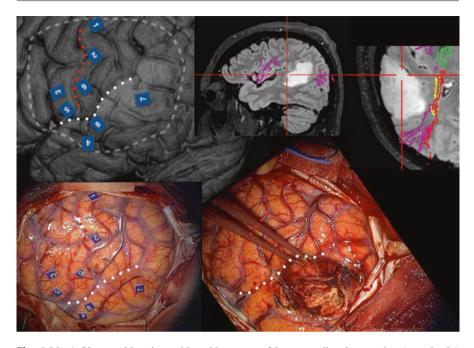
A 30-year-old patient with sudden onset of language disturbances that (completely) resolved after several hours. At time of admission to the hospital, there were no language or other impairments upon neurological examination. In retrospect, the patient reported that he experienced predominantly difficulties in word finding. In later days, the patient experienced auditory hallucinations. These temporary functional disturbances were considered epileptic phenomena. MRI (top *images*) revealed a left temporo-parietal brain tumour (low-grade glioma). MRI-based tractographic information is superimposed on anatomical images (purple, arcuate fasciculus; yellow, inferior fronto-occipital fasciculus; red, optical tract; green, corticospinal tract). The deepest part of the tumour is closely related to language and optical tracts. Dotted lines show the Sylvian fissure (white) and central sulcus (red). Photographs during surgery (bottom images) show the results of cortical stimulation and the extent of resection. Several tasks were used during the mapping procedure: counting, picture naming and auditory comprehension. (1) Sensation in the right hand; (2) sensation within the mouth; (3) number skipped during counting $(31 \dots 50)$; (4) hesitation and speech arrest; (5) speech arrest, "strange feeling" in the mouth; (6) sensation in the tongue; (7) hesitation. During five subsequent stimulations, no language impairments were found, and the area was considered noncritical for language; (8) hesitation, paraphasia and anomia. Subcortical stimulation in the resection cavity yielded visual sensations (in both eyes) and language disturbances (speech arrest, paraphasias). During tumour resection, there were mild language impairments that worsened in the days after surgery. Three months after surgery, at follow-up visit, these had been resolved
